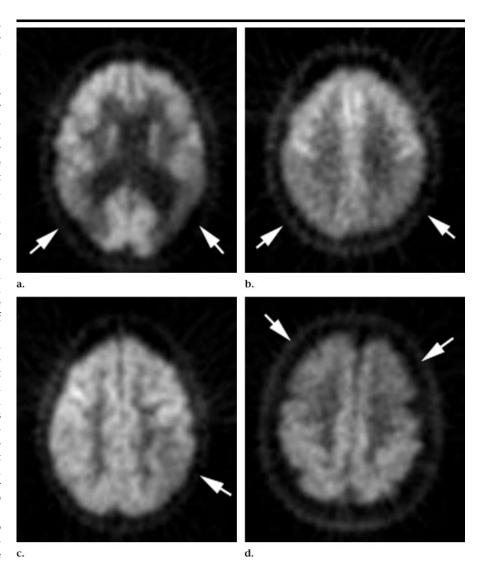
FDG PET images demonstrate typical findings in (a–c) three patients with AD and (d) one patient with frontotemporal dementia. (a) Note bilateral parieto-occipital hypometabolism (arrows) in a 77-year-old woman with AD. (b) Bilateral parietal hypometabolism (arrows) is also noted in a 62-year-old woman with AD. (c) Changes may be asymmetric, as demonstrated in a 53-year-old woman with AD, with the metabolic defect (arrow) primarily on the left. (d) As shown in a patient with frontotemporal dementia, PET may help differentiate frontotemporal dementia from AD by demonstrating metabolic deficits (arrows) in the frontal and anterior temporal lobes (not shown).
